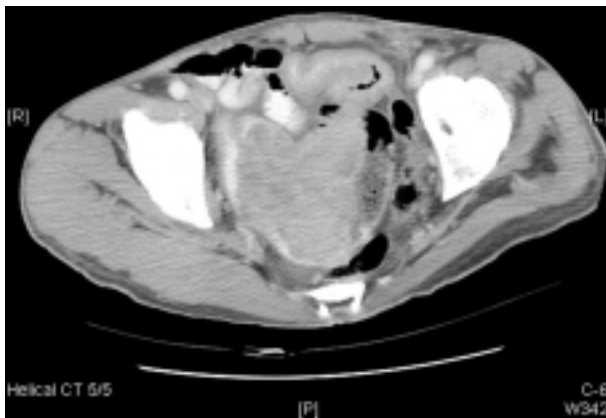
Abdominal computed tomography showing a huge polypoid mass in the small bowel loop in the pelvic cavity. The surface is lobulated with heterogenous enhancement. No enlarged regional lymph nodes are present in the abdomen.
